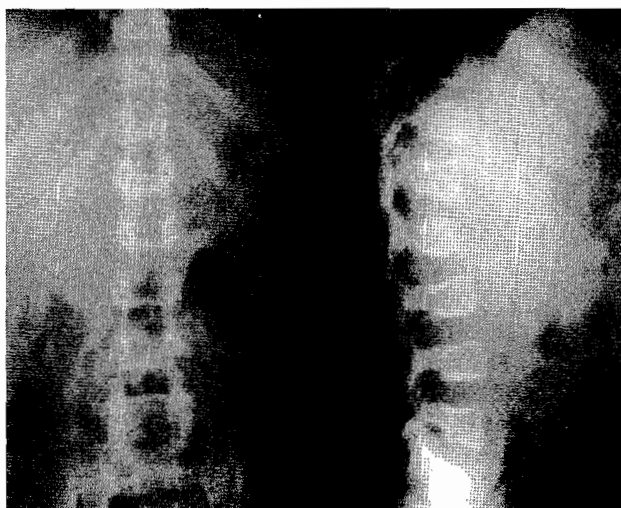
Plain radiographs of the lumbosacral spine showing oval shaped vertebrae with anterior-inferior beaking of T12 and L1.
